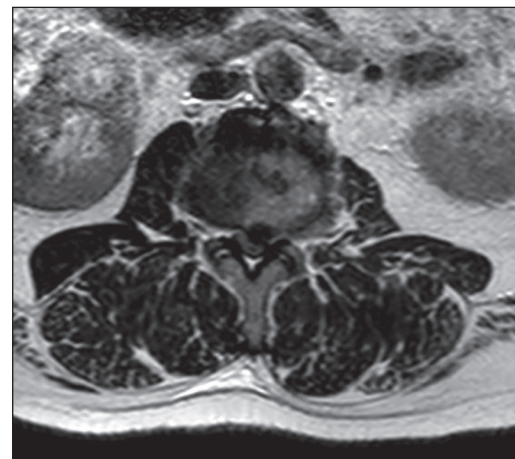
Lumbar MRI of same patient. He has left L4-5 disc herniation
